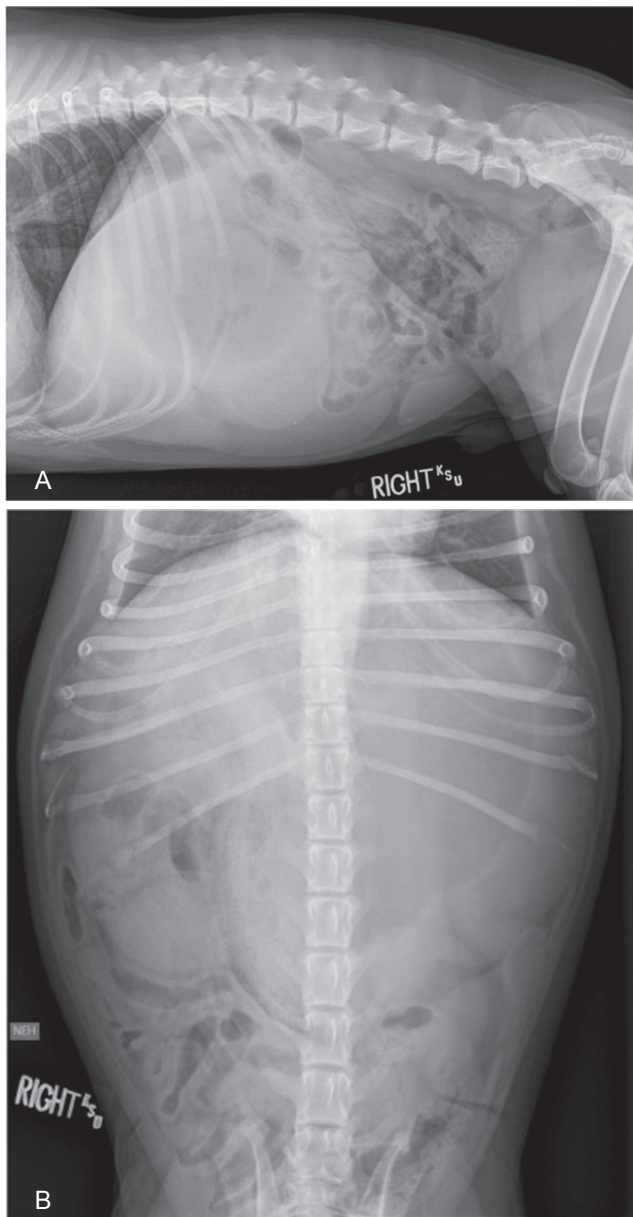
Right lateral (A) ventrodorsal (B) radiographic views of the abdomen of a 15-month-old male neutered English Bulldog evaluated because of acute vomiting and anorexia.
